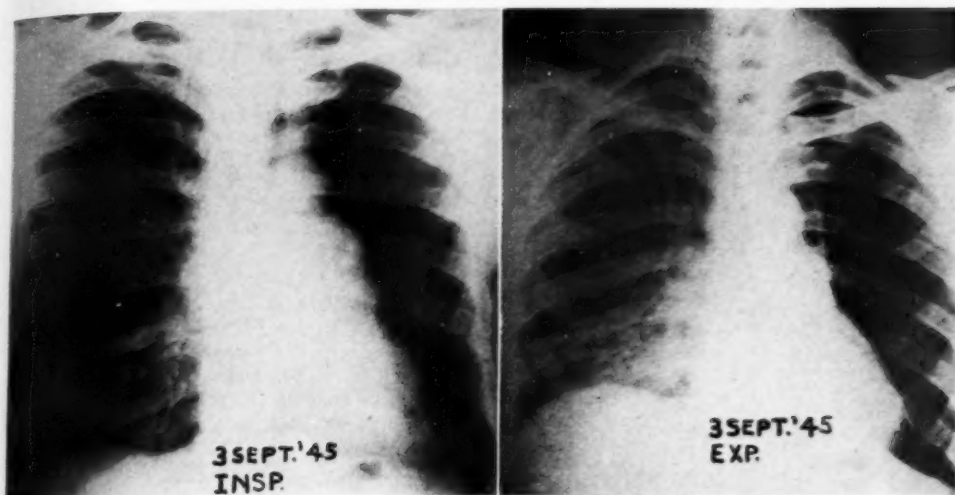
Case 3: Roentgenograms made at end of inspiration and expiration, Sept. 3, 1945.
